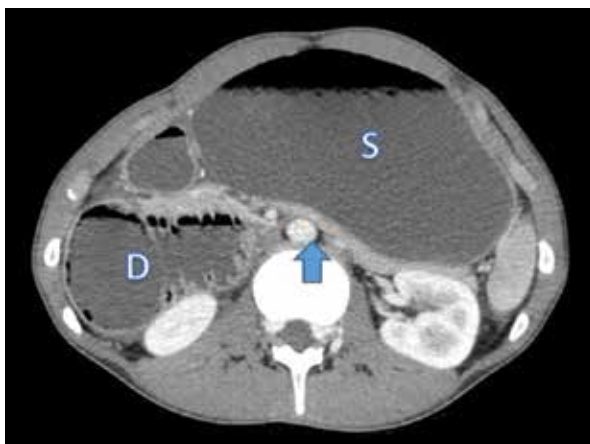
Axial image of a contrast-enhanced abdominal/pelvic computed tomography scan shows the markedly dilated, fluid-filled stomach (S) and the high-grade obstruction of the third portion of the duodenum (D) where it crosses the midline. The aorta is labeled with an arrow.
